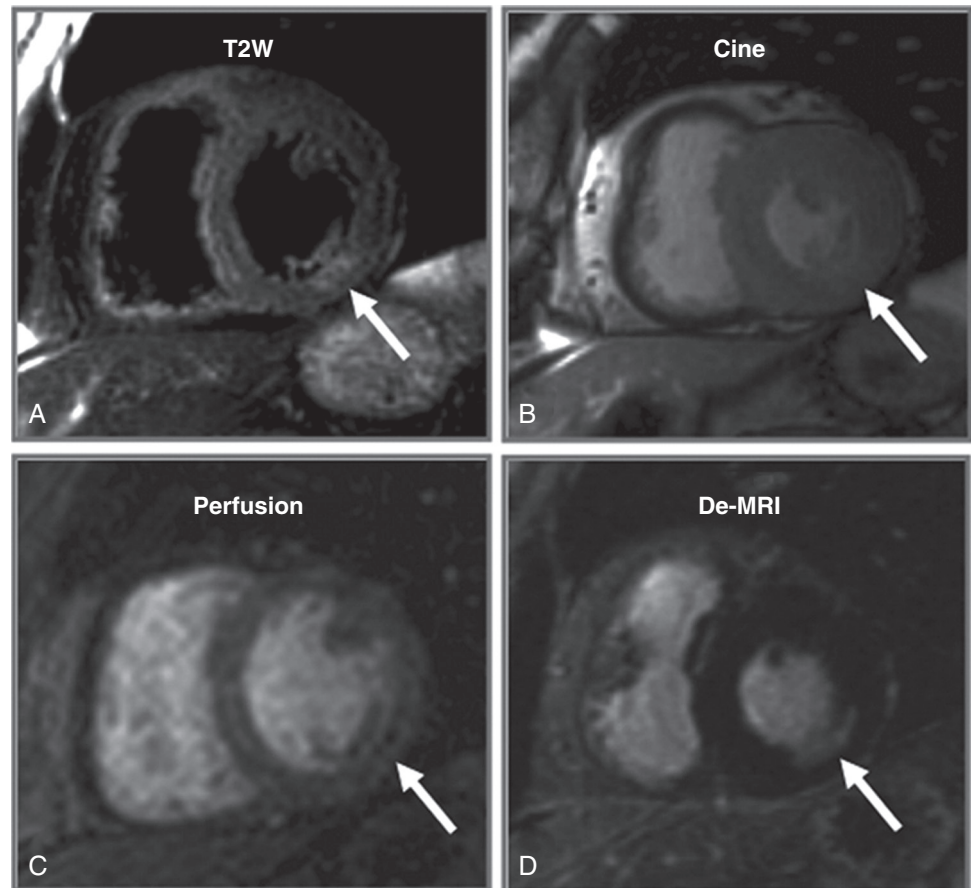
CMR assessment of acute coronary syndrome in a 63-year-old man 1 hour after his arrival at the emergency department. Initial cardiac enzyme levels were normal. A, A small area of T2 hyperintensity is evident in the inferolateral wall (myocardial edema), associated with subtle hypokinesis (B), a resting perfusion defect (C), and hyperenhancement on delayed imaging (De = MRI) (D), suggesting myocardial necrosis in the same area (arrows). Troponin level was elevated 7 hours after the imaging study. A subsequent invasive angiogram revealed triple-vessel disease with a 95% stenosis in the posterolateral branch. (From Cury RC, Shash K, Nagurney JT, et al: Cardiac magnetic resonance with T2-weighted imaging improves detection of patients with acute coronary syndrome in the emergency department. *Circulation* 118: 837, 2008.)
